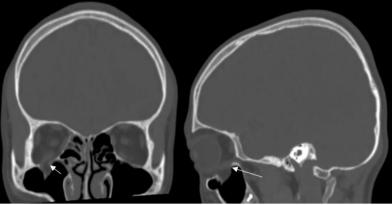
A 13 years old male patient with complaints of double vision on right eye post accidentally hitting the corner of the table. On CT scan coronal and sagittal view, there is a defect on the inferior orbital floor, with herniation of the orbital fat and partial of the inferior rectus muscle of the right eye (arrow). This is a case of orbital blow-out fracture, hinged type, without trapdoor appearance.
